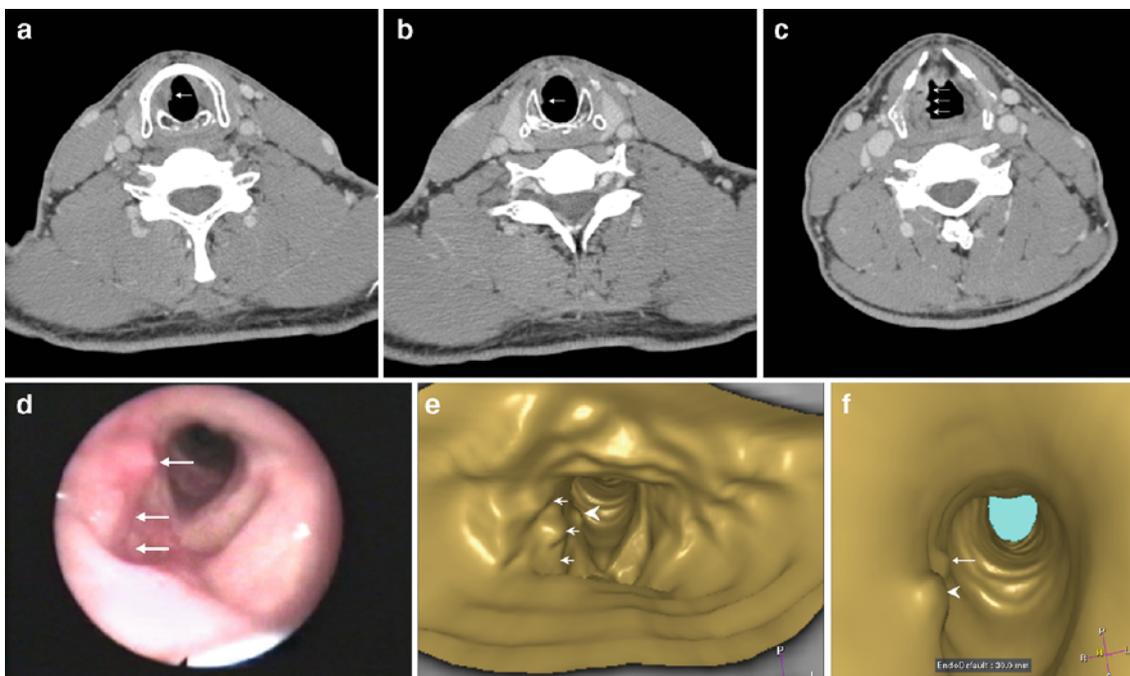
Transverse CT images (a-c) show multifocal carcinoma (arrows) involving the right vocal cord (a), and the right side of the subglottic (b) and supraglottic space (c). OE image (d) showing the right glottic-supraglottic tumor (arrows). VE images showing the right vocal cord lesion (arrowhead in e and f), right supraglottic lesion (e, arrows), and the right subglottic lesion (f, arrow).
